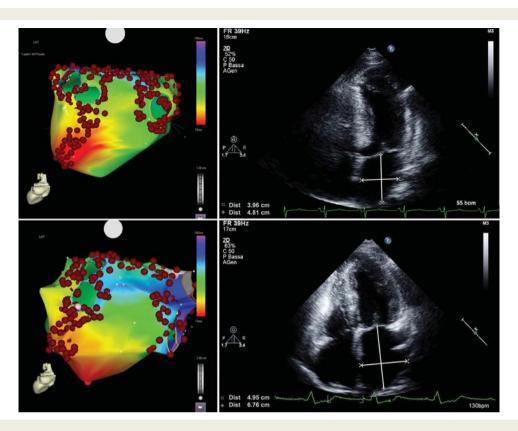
Figure I Radiofrequency catheter ablation of AF in two patients with HCM. Upper panels: A 50-year-old man with paroxysmal AF, in whom radiofrequency catheter ablation successfully restored sinus rhythm. Left: Three dimensional electroanatomic map reconstruction (PA view) of the LA showing pulmonary vein isolation and additional linear lesions. Right: Echocardiographic apical four-chamber view showing normal LA size. Lower panels: A 54-year-old woman paroxysmal AF, in whom AF recurred during follow-up. Left: Three dimensional electroanatomic map reconstruction (PA view) of the left atrium showing pulmonary vein isolation and additional linear lesions. Right: Echocardiographic apical four-chamber view showing markedly enlarged atrial size. HCM, hypertrophic cardiomyopathy; AF, atrial fibrillation; PA, postero-anterior; LA, left atrium.
